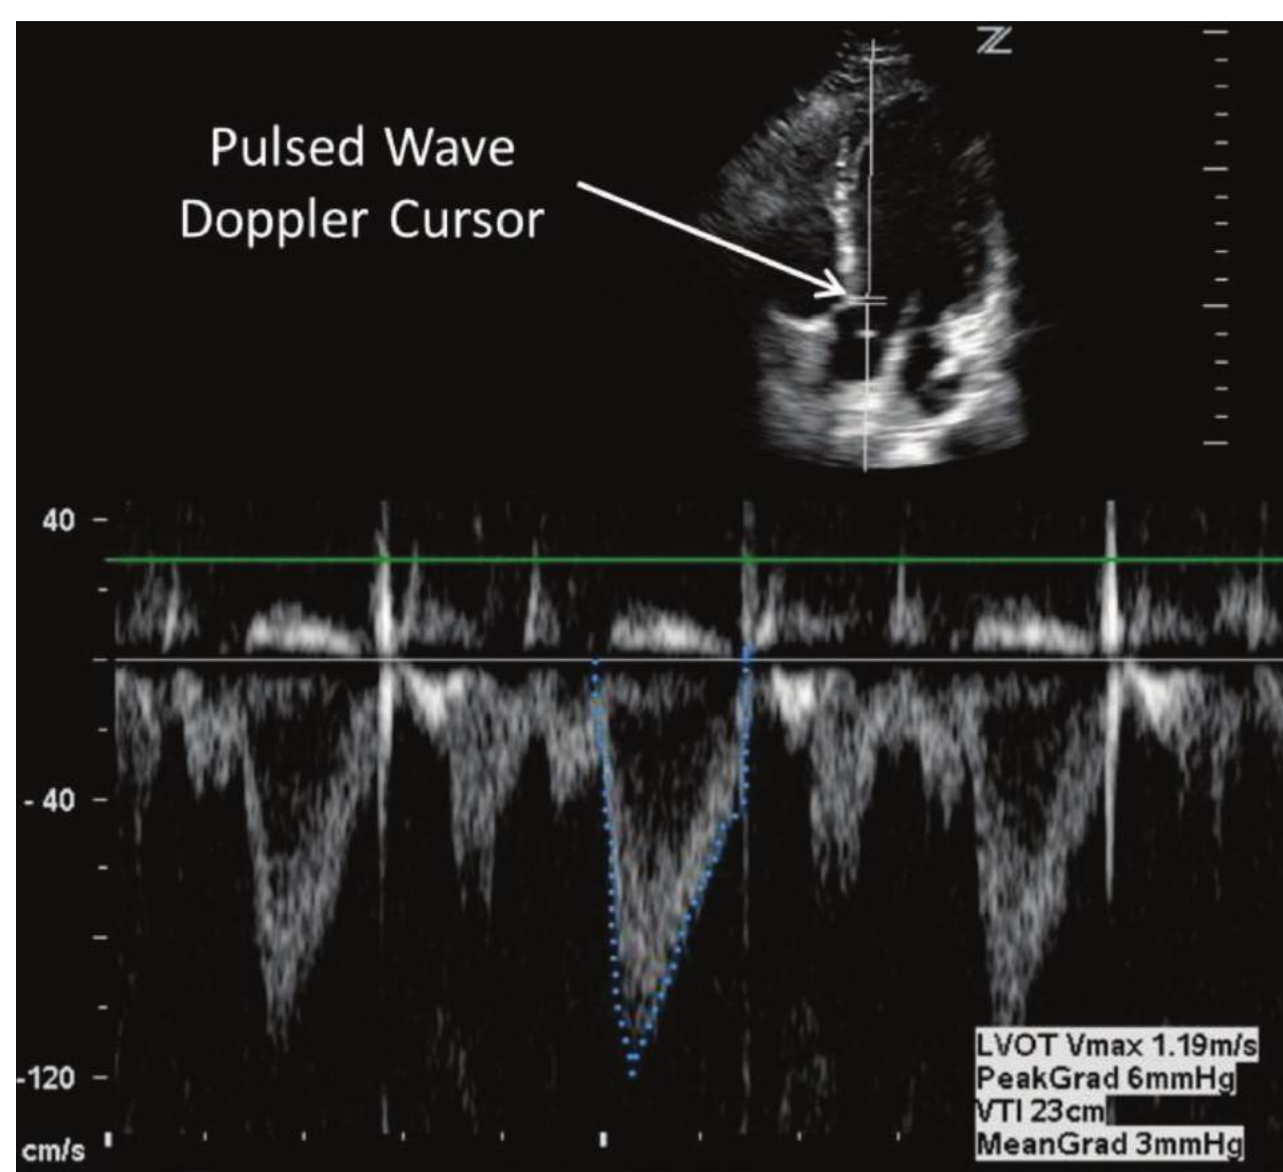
Measurement of VTI using the apical 5-chamber view. This view is obtained with the apical 4-chamber view and then angulating the probe slightly toward the patient's head until the LVOT can be visualized. The pulsed-wave Doppler cursor is placed at the LVOT, and the Doppler signal is traced (dotted lines) to calculate the VTI. (Reproduced with permission from Dinh VA, Ko HS, Rao R, Bansal RC, et al: Measuring cardiac index with a focused cardiac examination in the ED, *Am J Emerg Med*. 2012 Nov;30(9):1845–1851.)
